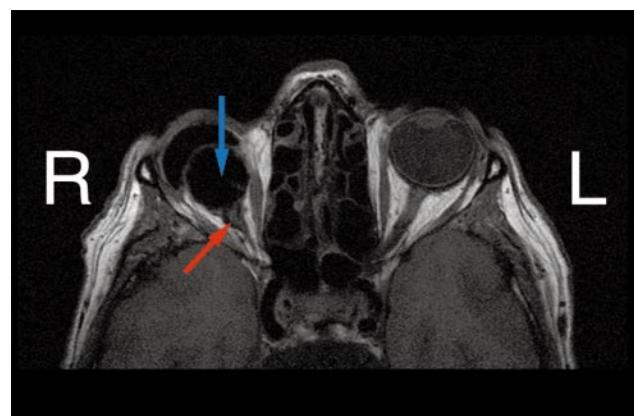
Static MRI for patient 15. Blue arrow: baseball implant attached to the optic nerve in the right orbit, with the prosthesis in front of it. Red arrow: junction of the optic nerve to the back of the sclera-covered implant.
